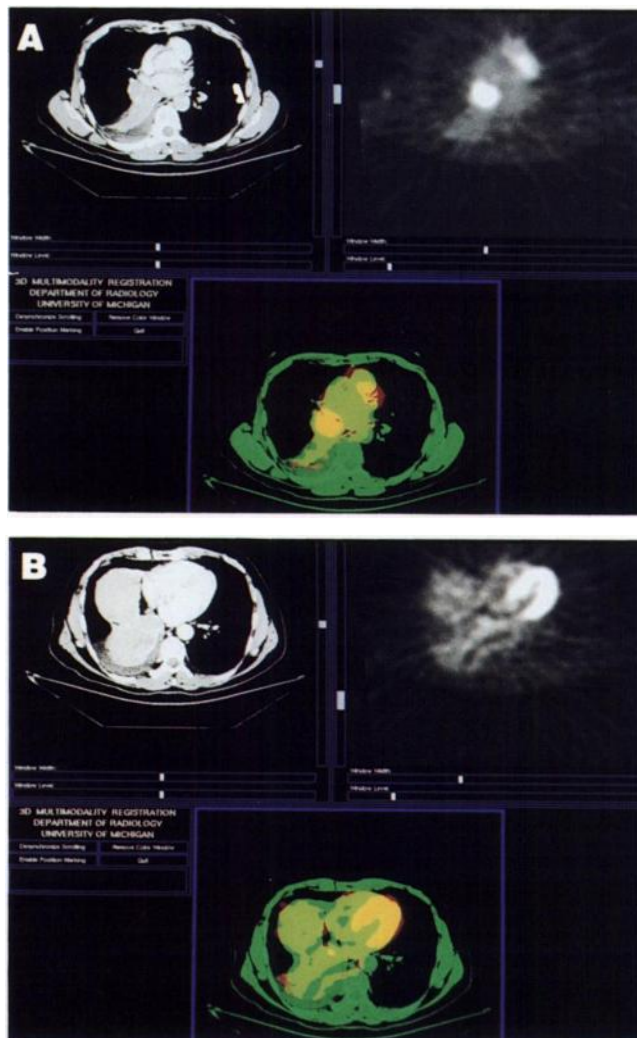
(A) CT shows marked volume loss in the right lower lung and a localized right pleural effusion in a patient with newly diagnosed lung cancer. The corresponding transverse emission PET image obtained at 60 min postinjection shows intense central FDG uptake in the right chest, modest focal FDG uptake in the anterior left chest, but only minimal FDG uptake in the blood pool and the collapsed right lower lobe/effusion area. The fusion image (bottom) clearly demonstrates intense FDG uptake in the central portion of the collapsed right lower lung most consistent with uptake in the central tumor, whereas the remainder of the right lung has activity most consistent with postobstructive volume loss. MRI performed elsewhere supported this interpretation and the large central tumor was treated nonsurgically. (B) A more caudal series of images from the same patient as in (A) demonstrates that the left anterior chest activity seen in (A) is myocardial in origin, with the left ventricular wall clearly delineated by PET, despite its poor delineation on the CT study. This is best seen on the fusion image.
